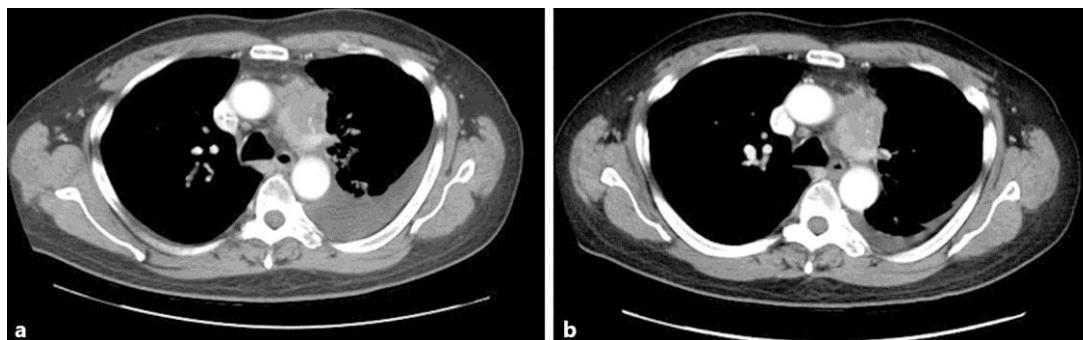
CT scans before and after treatment demonstrating a left-sided pleural effusion (a) before treatment with RRx-001 and (b) its near complete resolution after 6 weeks.
